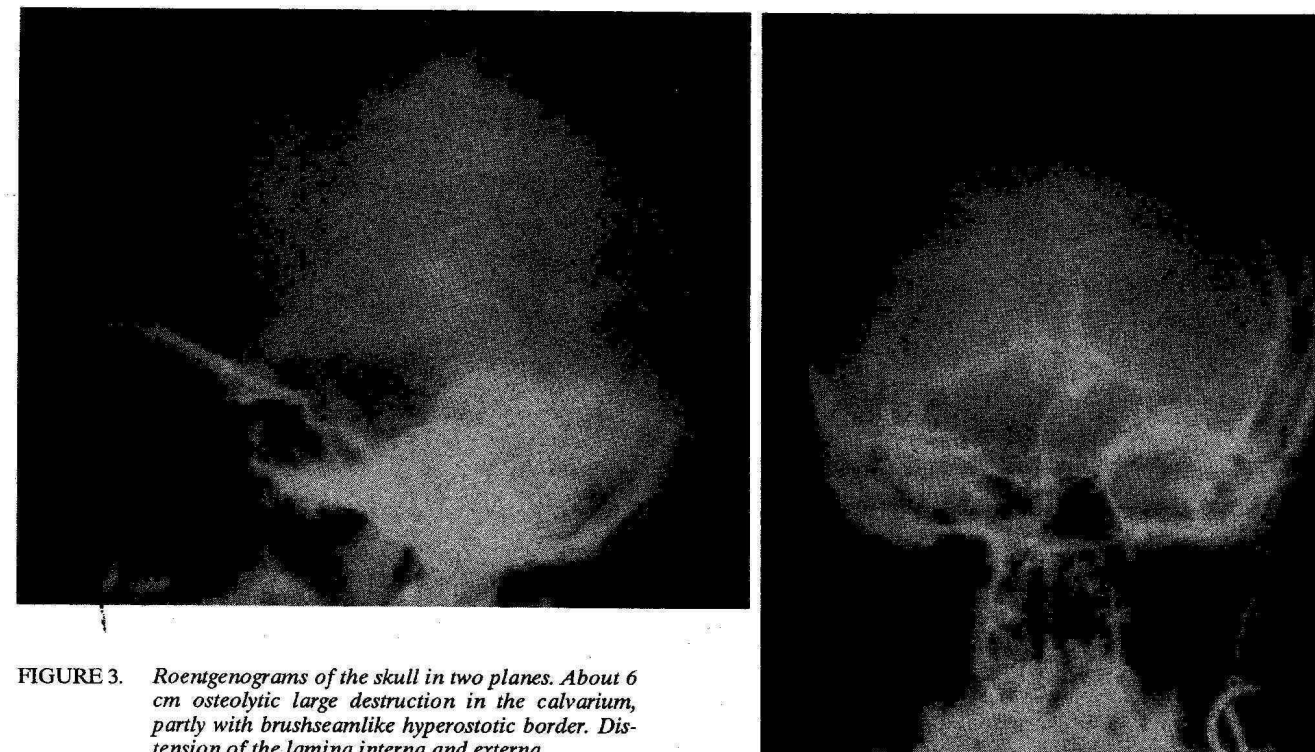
Roentgenograms of the skull in two planes. About 6 cm osteolytic large destruction in the calvarium, partly with brushseamlike hyperostotic border. Distension of the lamina interna and externa.
